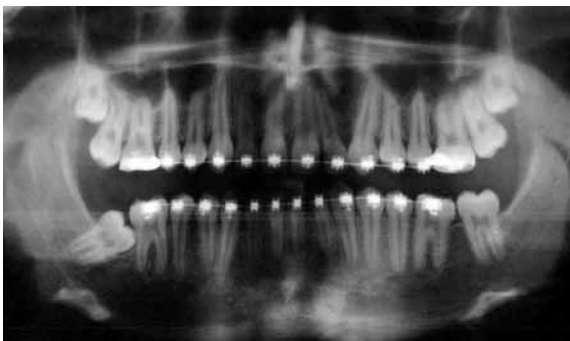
Initial panoramic radiograph shows impacted tooth 47.
